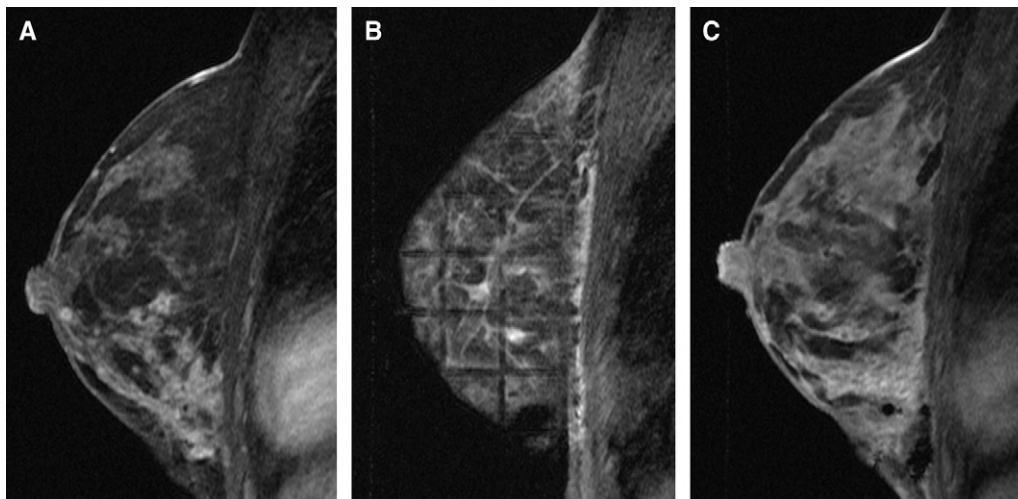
Segmental non-masslike enhancement in the lower breast seen on screening MRI in high-risk patient. (A) No abnormality was seen on mammography or ultrasound. Skin entry site of MRI-guided biopsy. (B) Obturator in good position within non-masslike enhancement. (C) Extensive non-calcified ductal carcinoma in situ was found on pathology.
